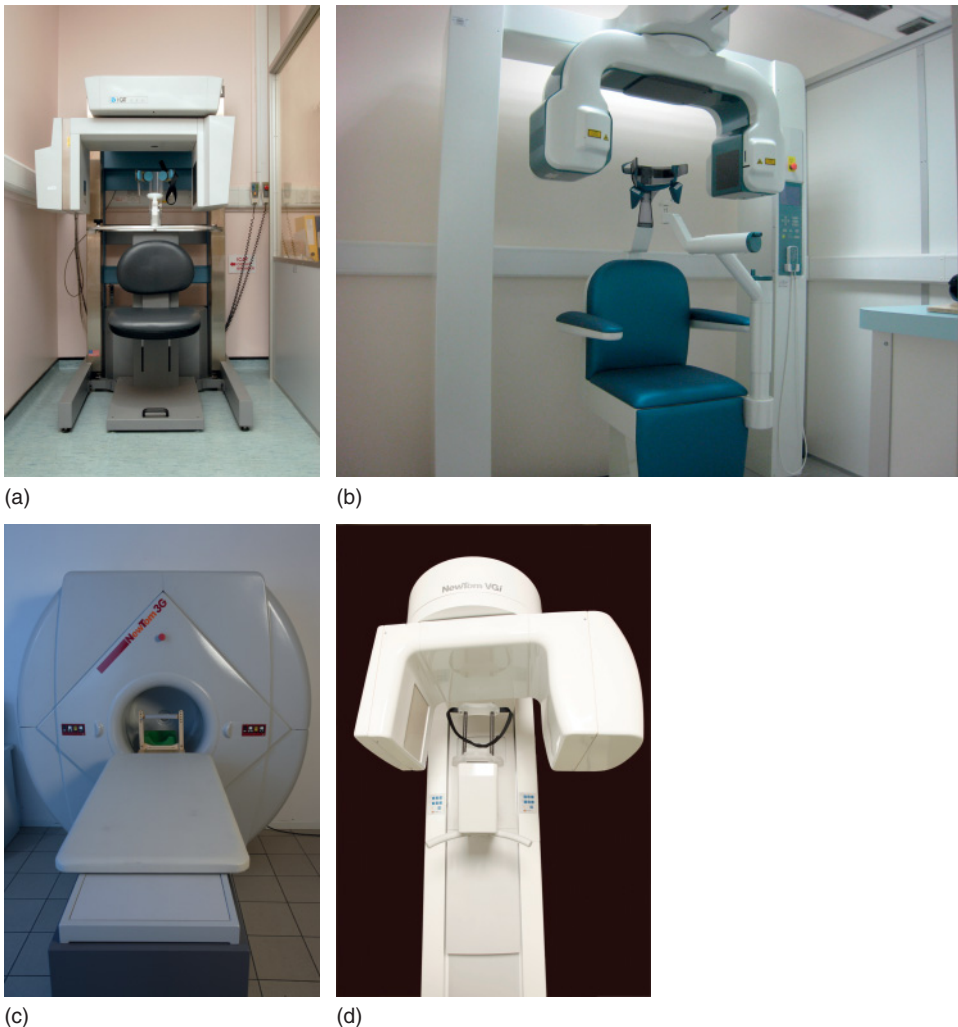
Examples of cone beam computed tomography units. (a) The Classic i-CAT (With permission from Imaging Sciences International, Hatfield, PA, USA and Cardiff University, UK). (b) The 3D Accuitomo (J. Morita Mfg. Corp., Kyoto, Japan). (With permission from the manufacturer (GmbH), courtesy of Eric Whaites, Department of Dental and Maxillofacial Radiological Imaging, King's College London, UK.) (c) The NewTom 3G (QR srl, Verona, Italy). (With permission from QR srl (Quantitative Radiology).) (d) The NewTom VGi (QR srl, Verona, Italy). (With permission from QR srl (Quantitative Radiology).)
